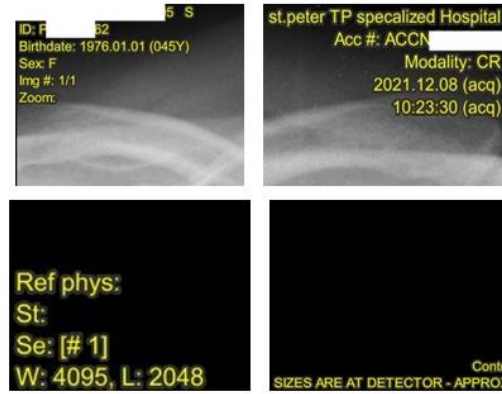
The Four Edges of a Single Local Chest X-ray Image
